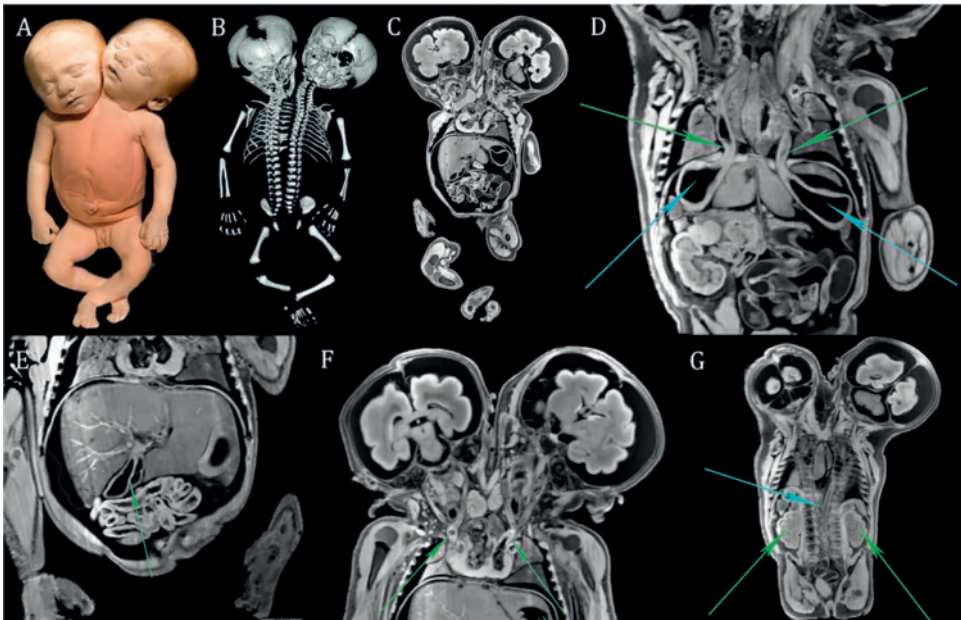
[A] Photograph of the full-term conjoined twin of case 3. [B] 3D reconstructed skeleton based on the CT data showed butterfly- and block vertebra with fused ribs between the two separate vertebral columns, two heads, two arms and two legs with one broad pelvis. [C] Coronal T1-weighted MR image showed two normal brains, one shared “fused” heart and liver with one overarching diaphragm. [D] Coronal T1-weighted MR image showed two separate esophagi (green arrows) and two separate stomachs (turquoise arrow). [E] Coronal T1-weighted MR image showed a “fused” liver with two gallbladders (green arrow). [F] Coronal T1-weighted MR image showed two ascending aortas (green arrows). [G] Coronal T1-weighted MR image showed two kidneys and adrenal glands (green arrows) and one anus. The two descending aortas fused at the level of the 11th thoracic vertebra (turquoise arrow). Note that the right descending aorta is smaller than the left descending aorta.
